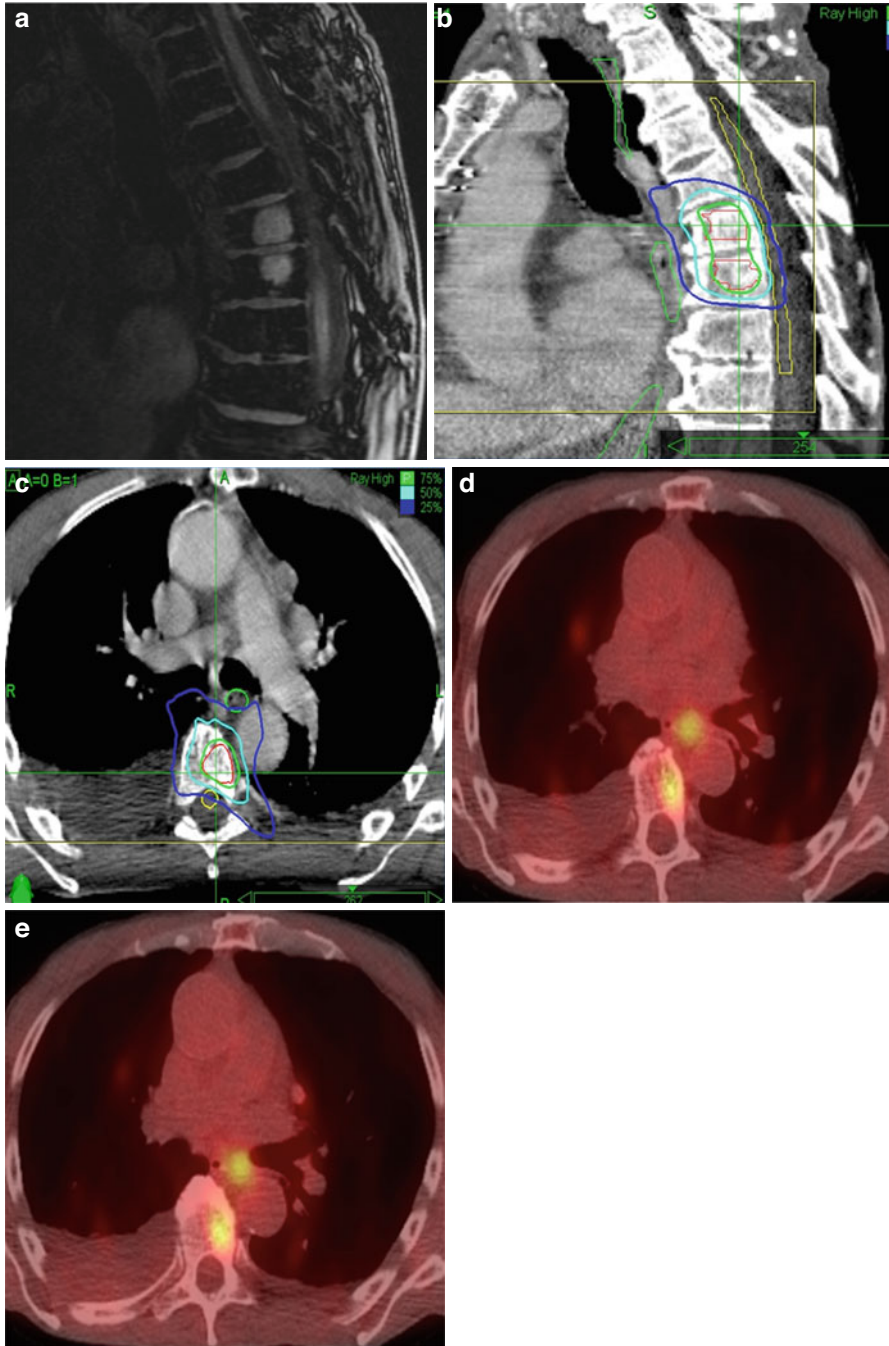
A 81 year old man with painful spine metastases at T6 and T7 of metastatic melanoma as demonstrated on sagittal MRI (a) and sagittal CT treatment plan (b). Axial treatment plan for T6 (c) outlined in *red* with each target treated to 20 Gy in 1 fraction the 75 % isodose line (ISL) shown in *green* with 50 % ISL in *cyan* and 25 % ISL in *blue*. Target volumes: 3.043 and 3.091 cm³. Maximum spinal cord dose 12.2 Gy. Maximum esophagus dose 10 Gy. Axial PET/CT images for each lesion (d, e)
